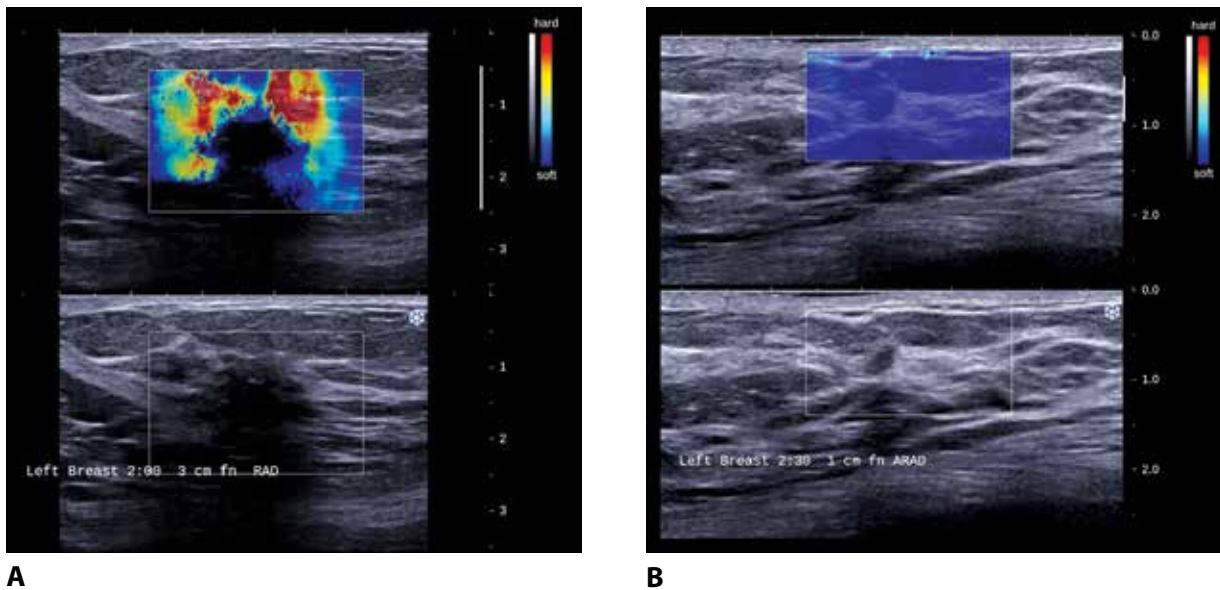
ELASTICITY ASSESSMENT: HARD (red depicted as hard and blue as soft). Invasive lobular carcinoma in two sites in left breast, the larger is HARD (*a*) and the smaller is soft (*b*). Both cancers have suspicious morphologic features on the gray scale sonograms displayed below the elastograms. The two cancers also were assessed as suspicious at both mammography and MRI (not shown). Take-home message: do not let a soft elastogram supersede morphologic analysis, especially when the imaging features on two or three different modalities suggest a suspicious assessment.
